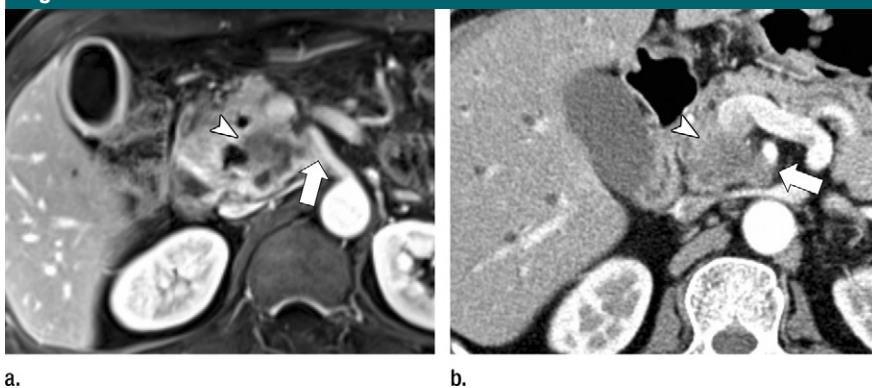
Images of pancreatic ductal adenocarcinoma in 62-year-old man. (a) Venous phase PET/MR image shows hypointense mass in uncinate process of pancreas abutting superior mesenteric artery (arrow). (b) Pancreatic phase multidetector CT image shows mass abutting superior mesenteric artery (arrow). This patient underwent R1 resection because of tumor invasion of superior mesenteric artery. Note that tumor conspicuity is higher at MR imaging (a) than multidetector CT (b) (arrowhead).
